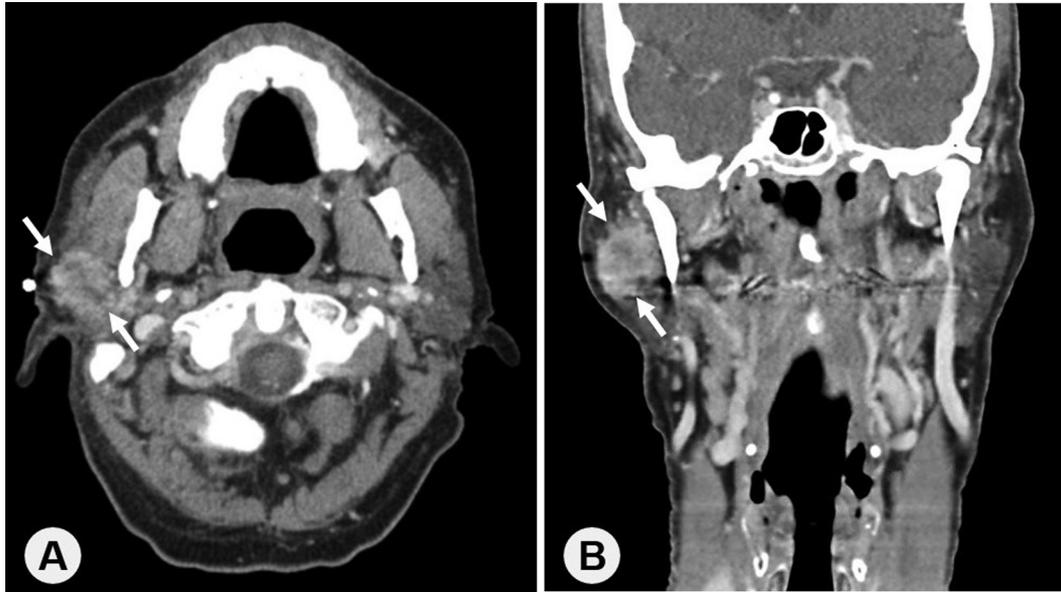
Radiological findings of the right parotid gland mass. Computed tomographic scan showing a 2.6 cm parotid mass (arrows) in the superficial lobe extending to about the retromandibular vein. (A) Axial view; (B) Coronal view.
